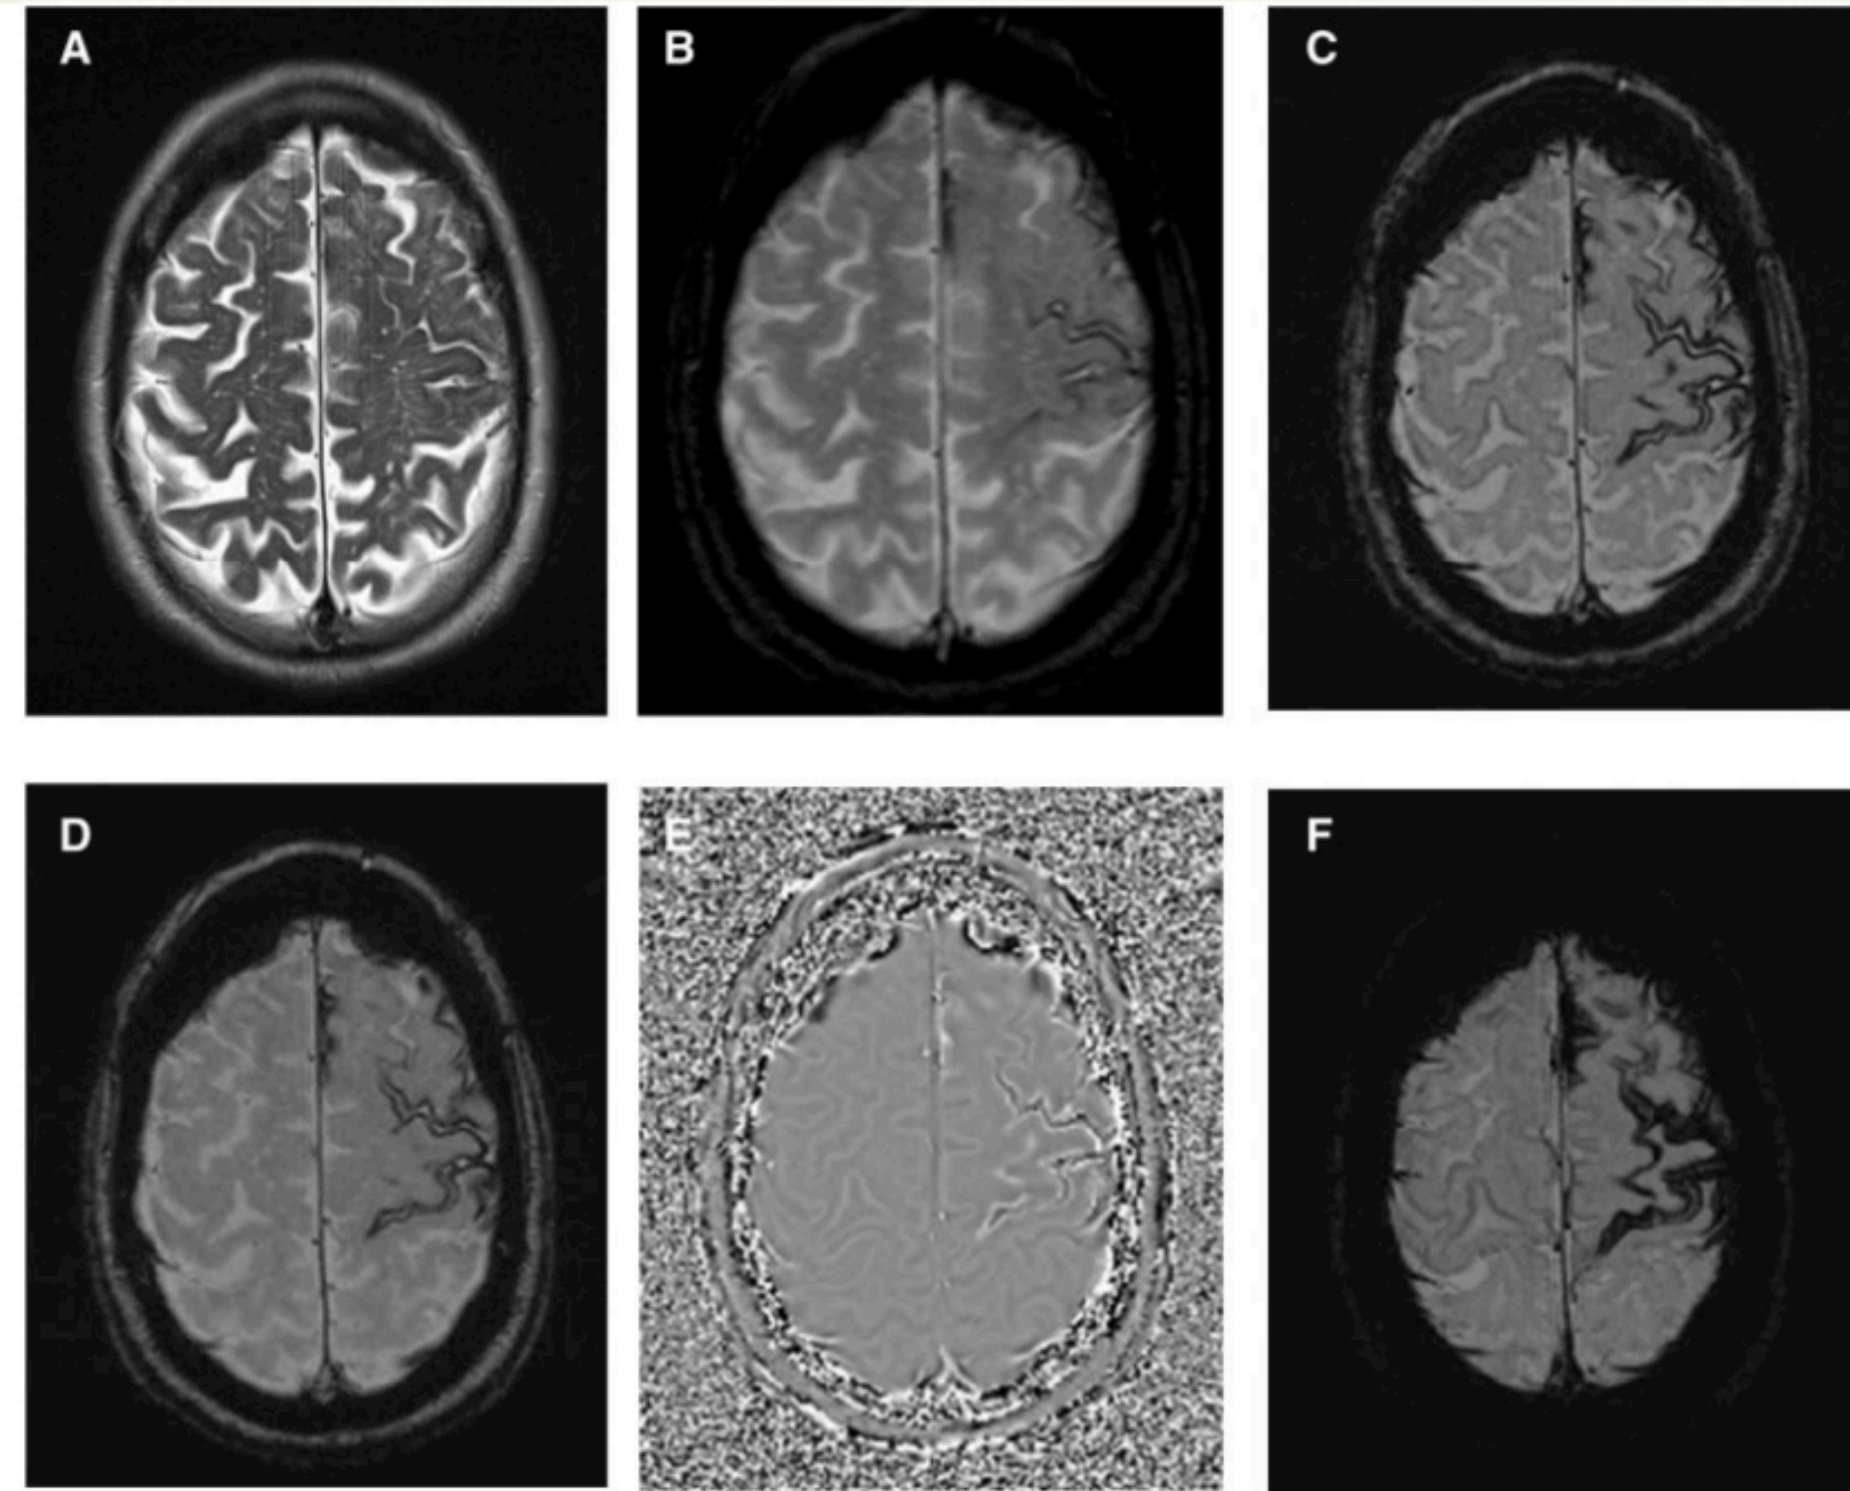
Detection of cSS on different MRI sequences. Axial slices through superior cerebral convexity in a patient with probable CAA. The T₂-weighted image (A) shows no cSS, while the T₂*-GRE (B) shows cSS as curvilinear low signal intensity areas on the surface of the left frontal gyri. SWI imaging (C–F): susceptibility-weighted image (C) is produced by the magnitude image (D) multiplied with a filtered phase image (E), which demonstrates more widespread and more conspicuous cSS than the T₂*-weighted GRE (B). The conspicuity of the cSS and of cortical veins is further enhanced in the minimum intensity projection image (F).
